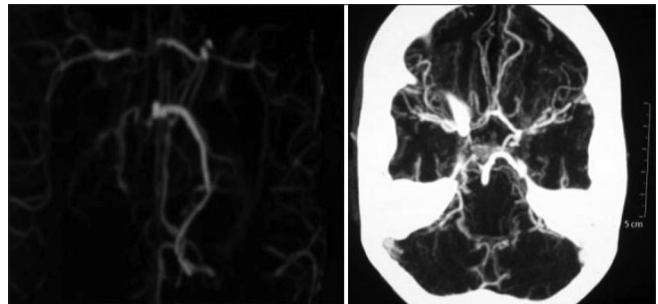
Computed tomography angiography brain showing occlusion of bilateral supraclinoid internal carotid arteries and proximal middle cerebral arteries with collaterals at the base of the brain suggestive of moyamoya disease along with stenosis of P1 segment of right posterior cerebral artery
